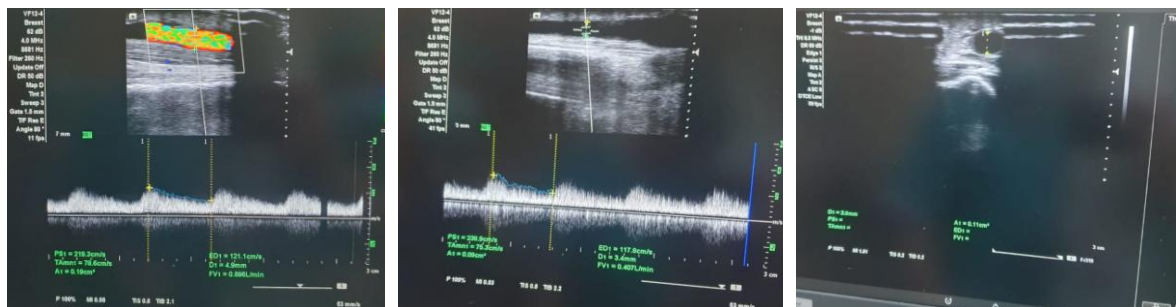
Vascular ultrasound of the cephalic vein
